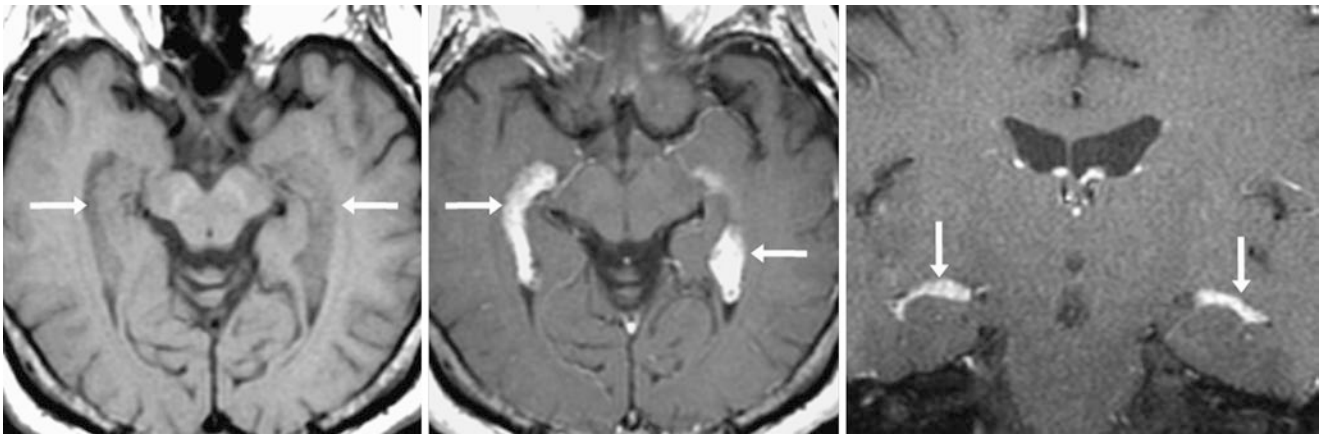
A 57-year-old patient was given a 1.5 T MRI, including an axial T1WI (*left*) that demonstrated a prominent CP (*arrows*) within the trigones and temporal horns that avidly enhanced on postcontrast axial
